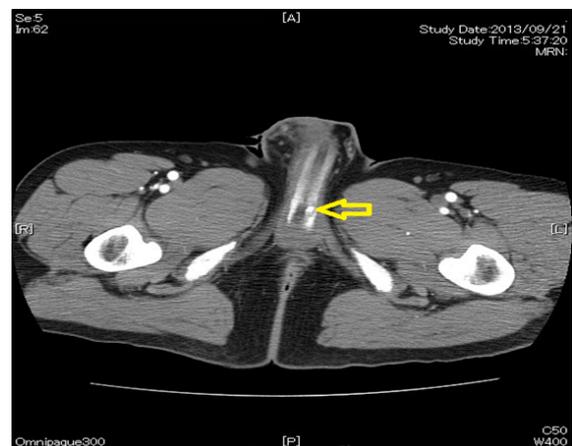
Enhanced CT revealed a suspicion of a pseudoaneurysm on urethra (Arrow).
